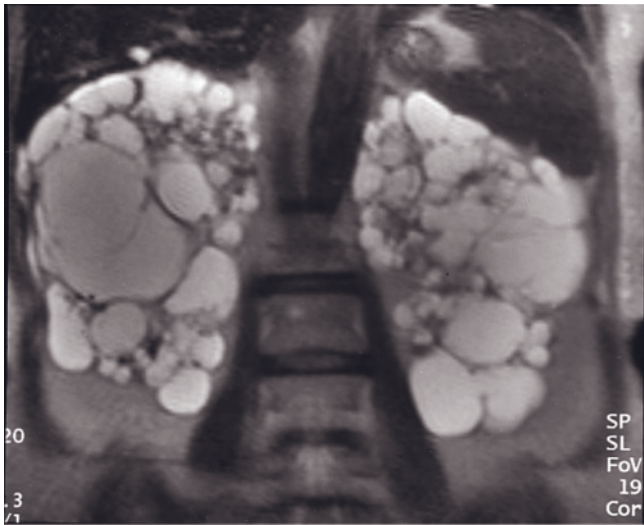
Autosomal dominant polycystic kidney disease. Coronal (a) and transverse (b) T2-weighted SS-ETSE and transverse T1-weighted precontrast (c) and late fat-suppressed postgadolinium (d) SGE images. The kidneys are greatly enlarged, with numerous cysts. The majority of the cysts demonstrate high signal intensity on T2- and low signal intensity on T1-weighted images consistent with simple cysts, but a sizable fraction have varying signal consistent with blood products of differing age. Postgadolinium image (d) demonstrates no dominant enhancing areas worrisome for neoplasm. Coronal T2-weighted SS-ETSE (e) and transverse T1-weighted fat-suppressed postgadolinium SGE (f) images in a second patient show the same findings described above. Evaluation for neoplasm in cystic kidneys such as these is difficult because of the varying signal of cysts. Transverse
